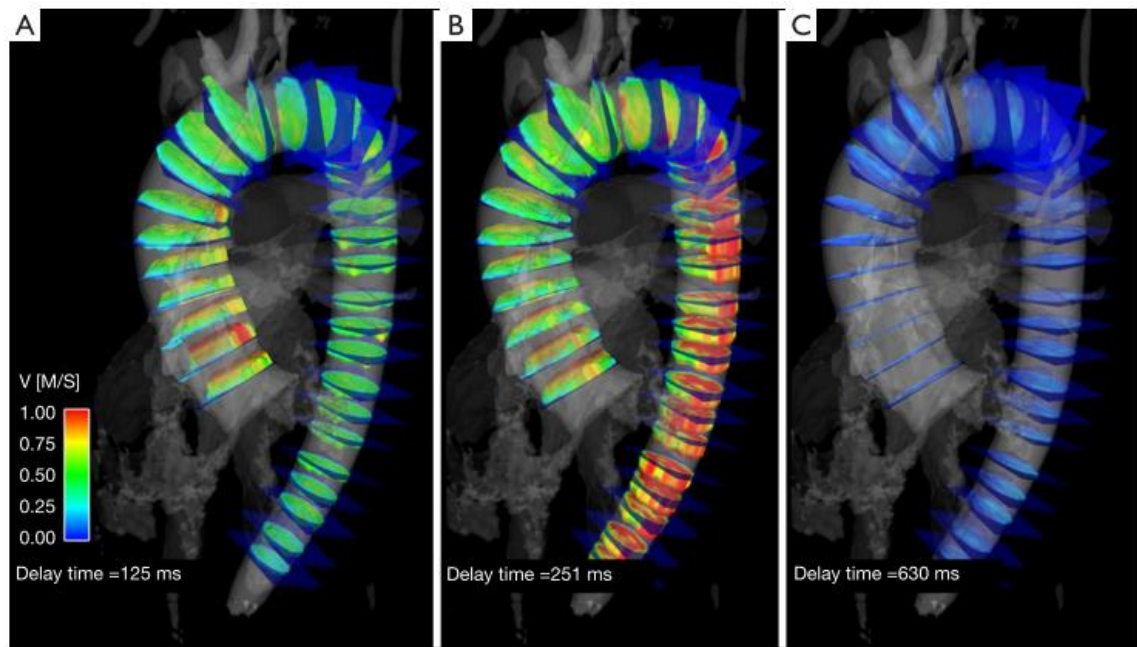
4D phase contrast MRI: The assessment of PWV of a healthy volunteer is shown in 3 out of 20 cardiac phases with delay time 125 ms, 251 ms and 630 ms. The velocity data is highlighted using velocity vectors and overlaid on the anatomical data (greyscale). As reproduced from (Wentland *et al.* 2014).
